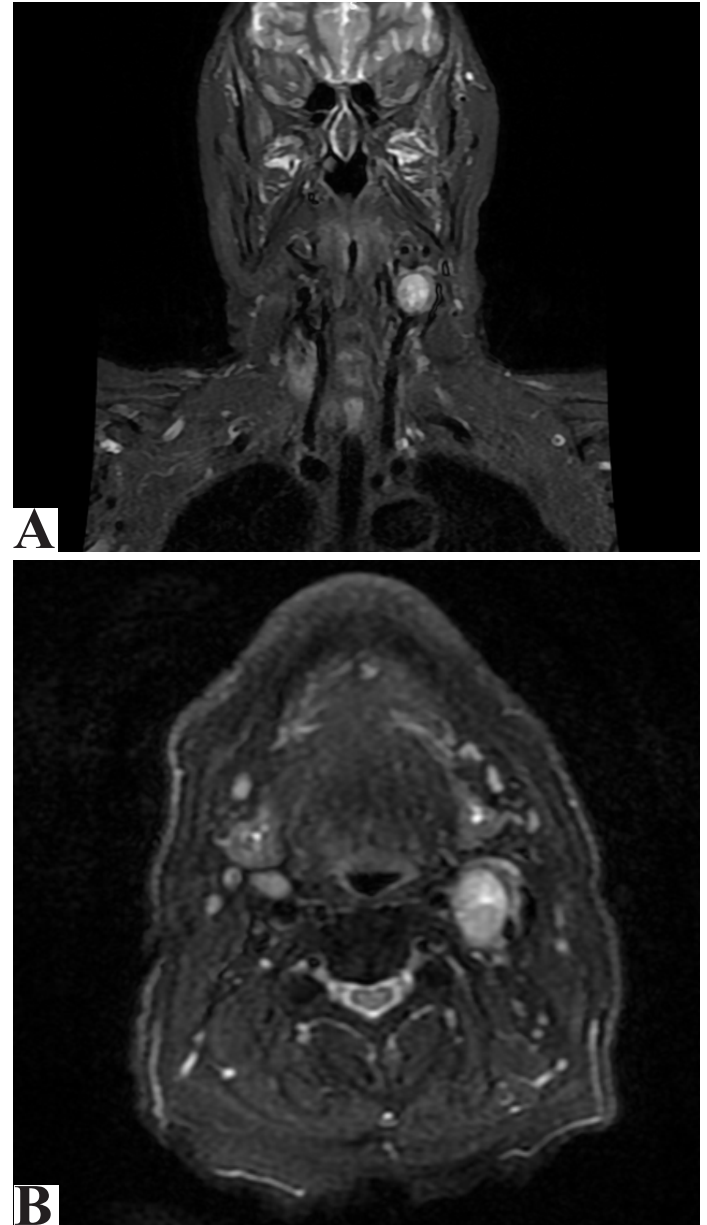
Magnetic resonance imaging (MRI) of a carotid body tumor; (A) Coronal view demonstrating a well-defined mass located at the level of the carotid bifurcation; (B) Axial view showing the relationship between the tumor and the surrounding vascular structures
